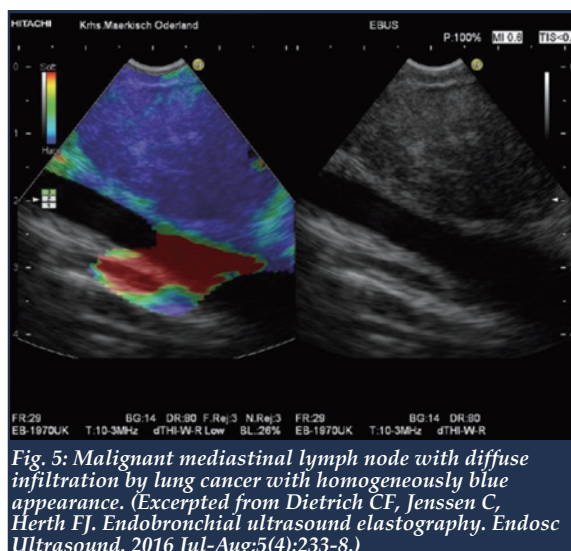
Malignant mediastinal lymph node with diffuse infiltration by lung cancer with homogeneously blue appearance. (Excerpted from Dietrich CF, Jenssen C, Herth FJ. Endobronchial ultrasound elastography. *Endosc Ultrasound*. 2016 Jul-Aug;5(4):233-8.)
